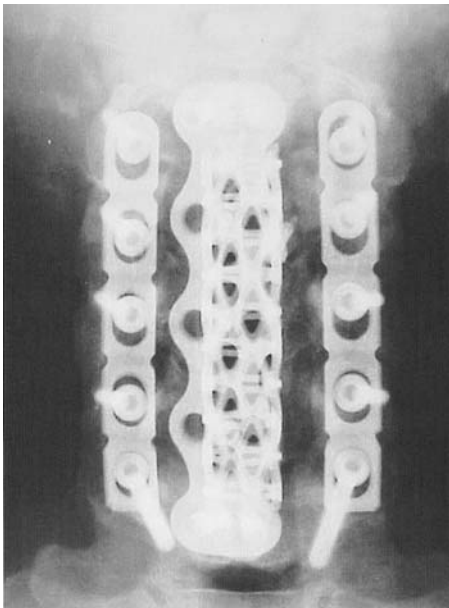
Postoperative AP radiograph demonstrating multilevel decompression and reconstruction with titanium mesh, anterior plate, and lateral mass and pedicle plates and screws.
